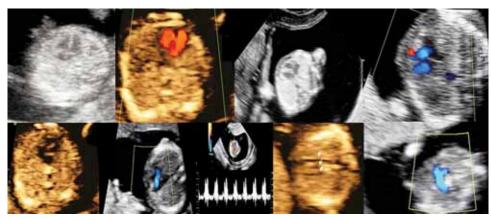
Early fetal echocardiography by transvaginal 2D US. Normal four chamber view through a transverse section of the fetal chest can be seen at different gestational ages. Color Doppler evaluation of ventricular septum to diagnose VSD. Aortic outflow, pulmonary artery crossing over the aorta shown by color flow can be seen. Flow at the tricuspid valve can help us to diagnose chromosomal abnormalities at the first trimester. Three vessel view showing normal outflow tracts. Color flow also helps us to better visualize the outflow tracts
